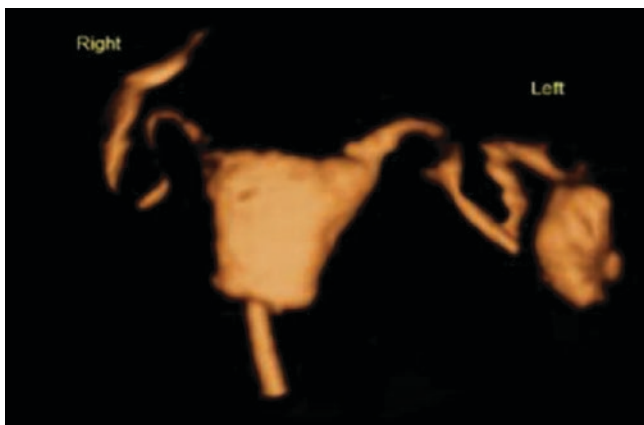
Salpingography of the partially obstructed fallopian tube (positive contrast agent). 3-D ultrasonography shows the partially obstructed right fallopian tube, and the left fallopian tube hydrops
